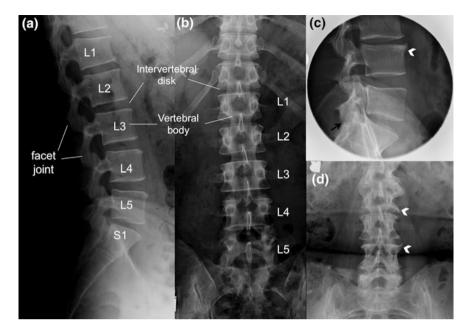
Plain radiograph of a normal lumbar spine and of lumbar spondylosis. a Lateral view of a normal lumbar spine. b Anteroposterior view of a normal lumbar spine. c Lateral view of a patient with lumbar spondylosis. Marginal osteophyte (*arrowhead*) and narrowing of a facet joint (*arrow*) are present. d Anteroposterior view of a patient with lumbar spondylosis. Notice the marginal osteophytes (*arrowhead*) at multiple levels
